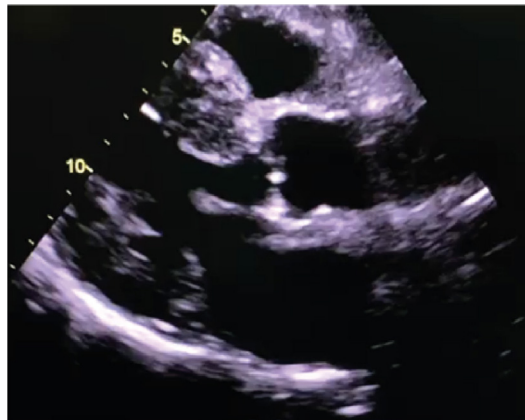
Longitudinal parasternal image of the left ventricle showing increased wall thickness, a granulated myocardium (suggestive of deposit disease), increased mitral and aortic valve thickness, and increased endocardial refringence (binary sign).
